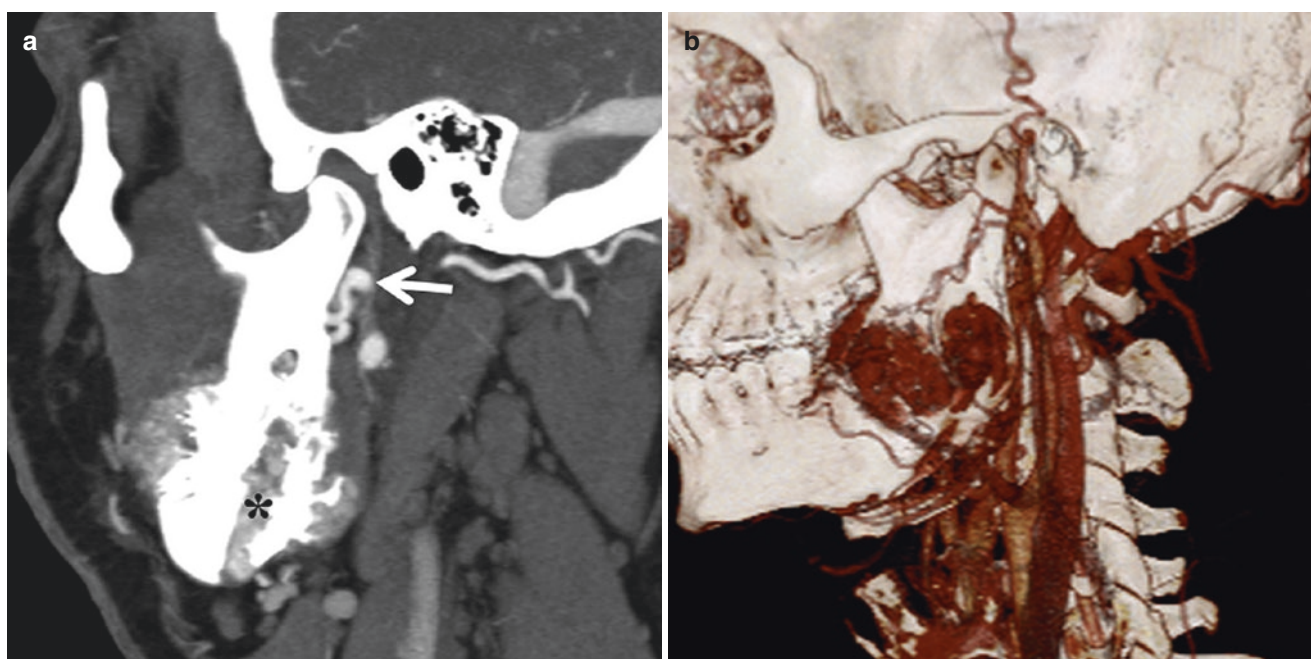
Mandibular AVM. A 31-year-old presents with hemorrhage after a dental procedure. (a) Sagittal MIP CTA demonstrates a lytic hypervascular mass in the left mandibular ramus (*), mostly supplied
